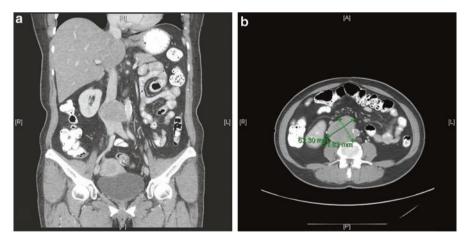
CT scan (a, b) of high-grade leiomyosarcoma of inferior vena cava
